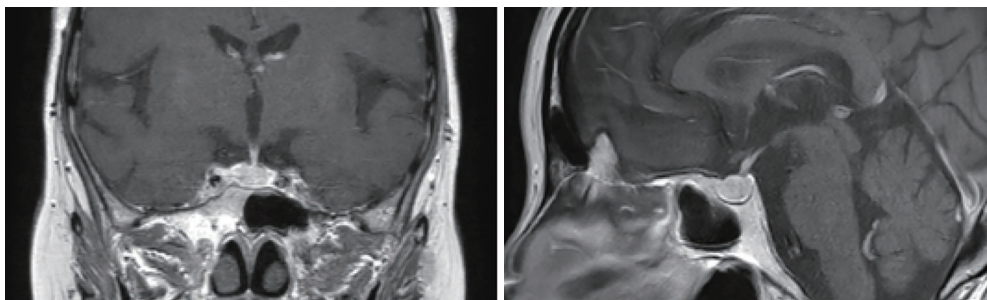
Brain MRI showed no delayed enhancement in Pituitary gland region.
